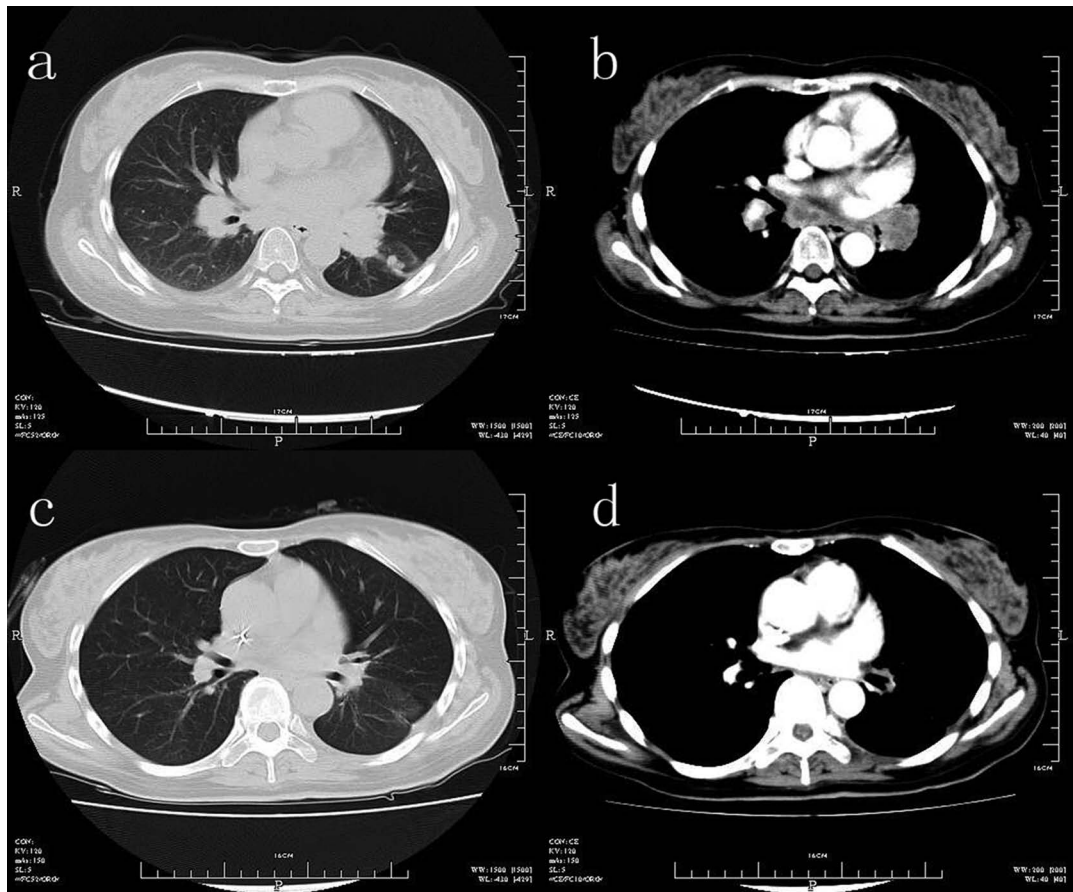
CT scan of the chest revealed a lobulated nodular lesion in the left lobe with enlargement of mediastinal lymph nodes (a, b); both the nodular lesion and the lymph nodes were reduced in size after 12 weeks of treatment with ceritinib (c, d).
